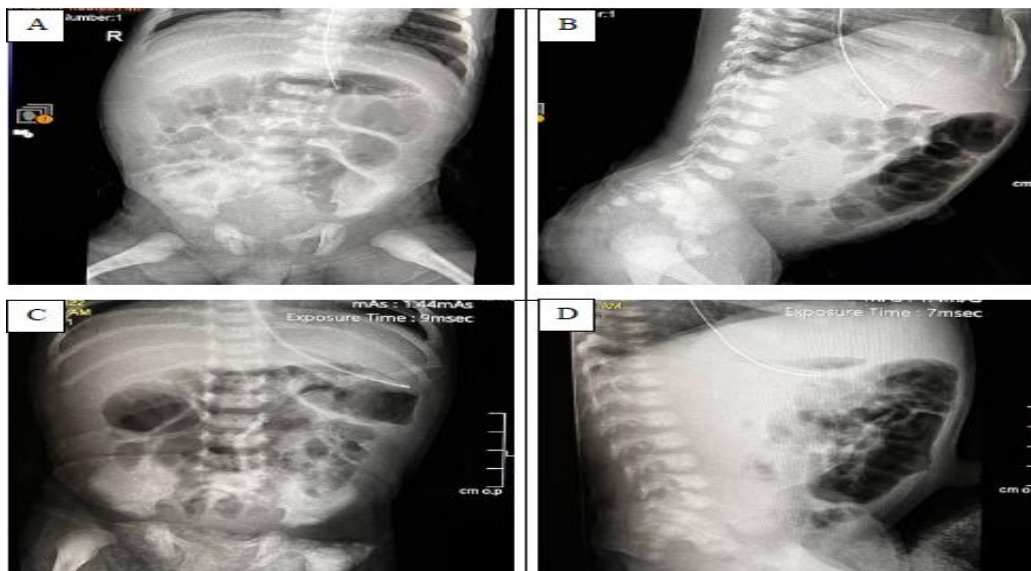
(A) and (B) Abdominal radiographs taken during first hospital day showed presence of gas-dilated loops of bowels, disorganized in pattern with no evidence of pneumoperitoneum. Impression: To consider adynamic ileus. (C) and (D) Abdominal radiographs on the second hospital day showed no significant change in the degree and number of gas filled bowel loops. Neither high-grade obstruction nor evidence of pneumoperitoneum was seen. Impression: No significant change in presumed ileus.
